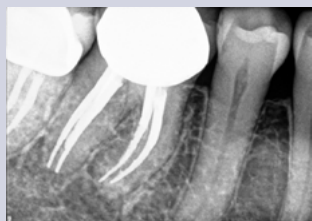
Periapical radiograph of tooth #30.
